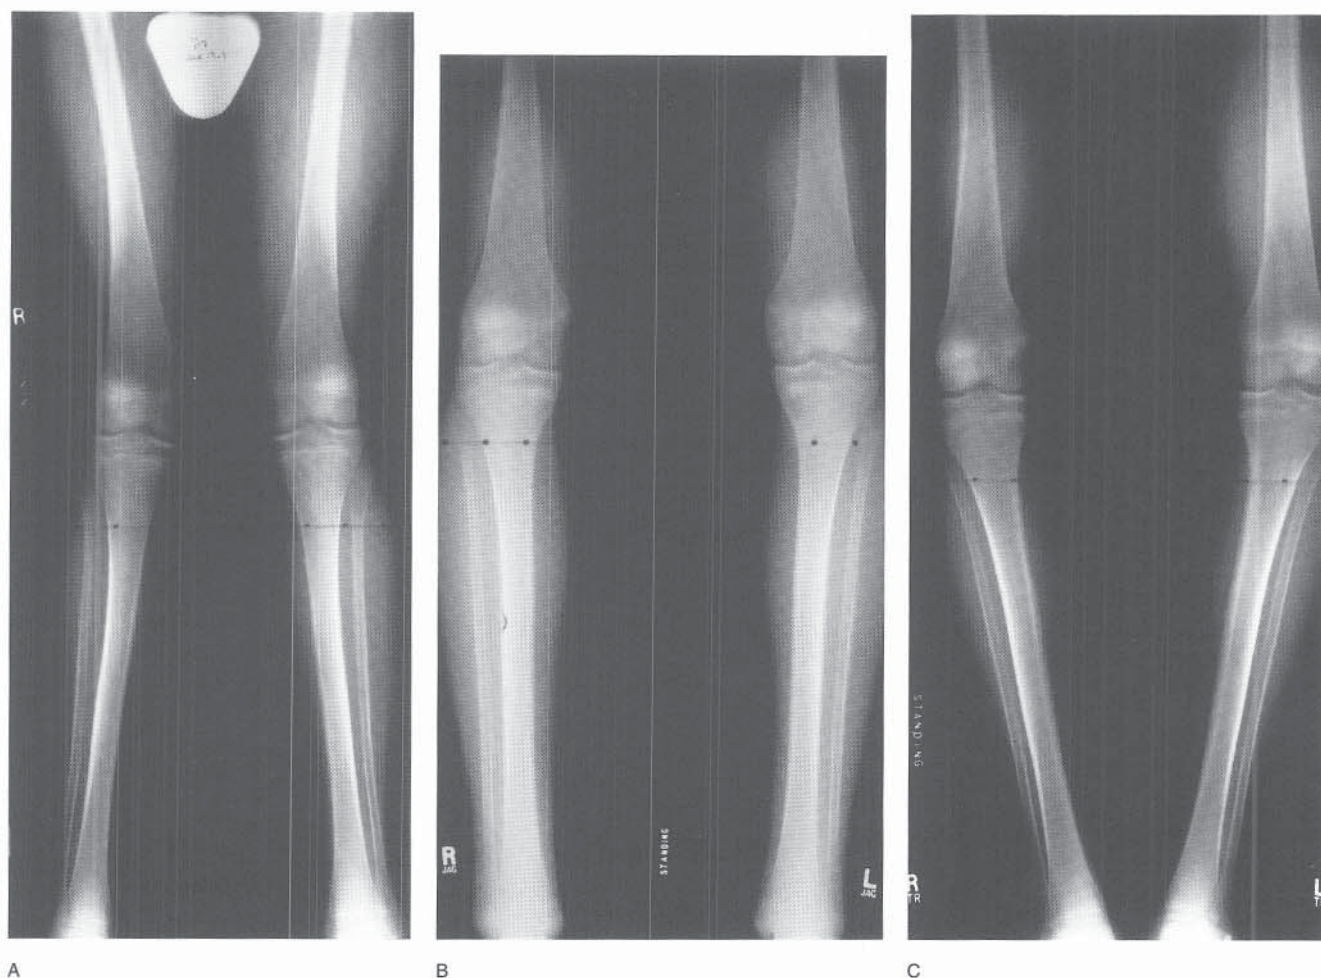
A, Preoperative bilateral genu valgum in a 14-year-old boy. Because his bone age was only 13 years 6 months (i.e., 2 years of growth remaining), a permanent hemi-epiphysiodesis was delayed an additional 9 months. B, Radiographic appearance 6 months after medial distal femoral and proximal tibial hemiepiphysiodesis. Correction was deemed complete, and closure of the lateral physes was scheduled. C, The patient failed to return for closure of the lateral physes until an additional 6 months had passed. Genu varum resulted, owing to continued lateral physal growth.
